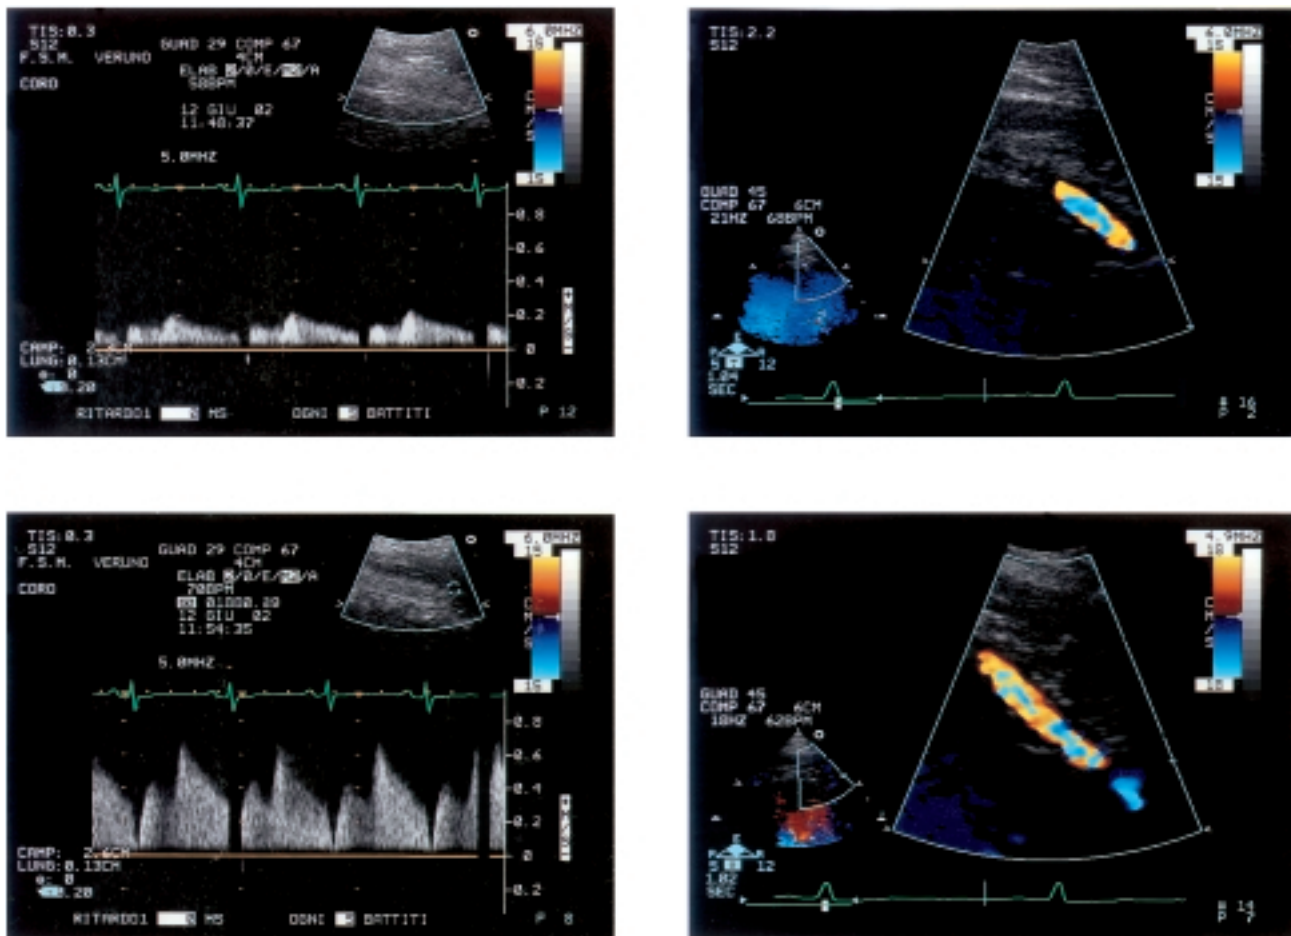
Pulsed wave Doppler flow recording and color flow visualization of the left anterior descending coronary artery in basal conditions (top) and during adenosine infusion (bottom); coronary flow reserve = 3.
